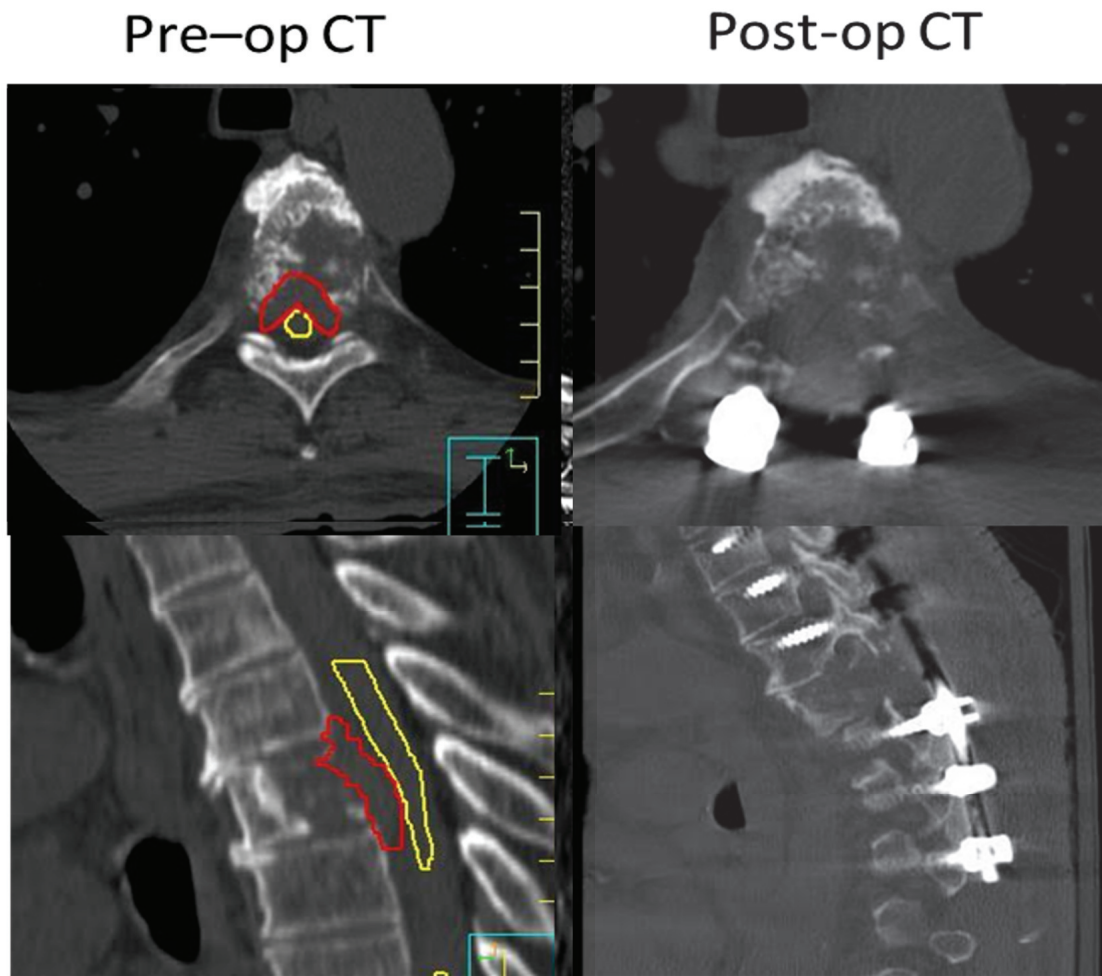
Pre- and post- operative spine separation surgery: Axial and sagittal CT images demonstrating pre-surgical spinal cord (yellow) and epidural disease (red) contours. Epidural disease contours identify tissue targeted for resection (left panel). Postoperative axial and sagittal CT demonstrates instrumentation above and below the diseased vertebral body with bone removed.
